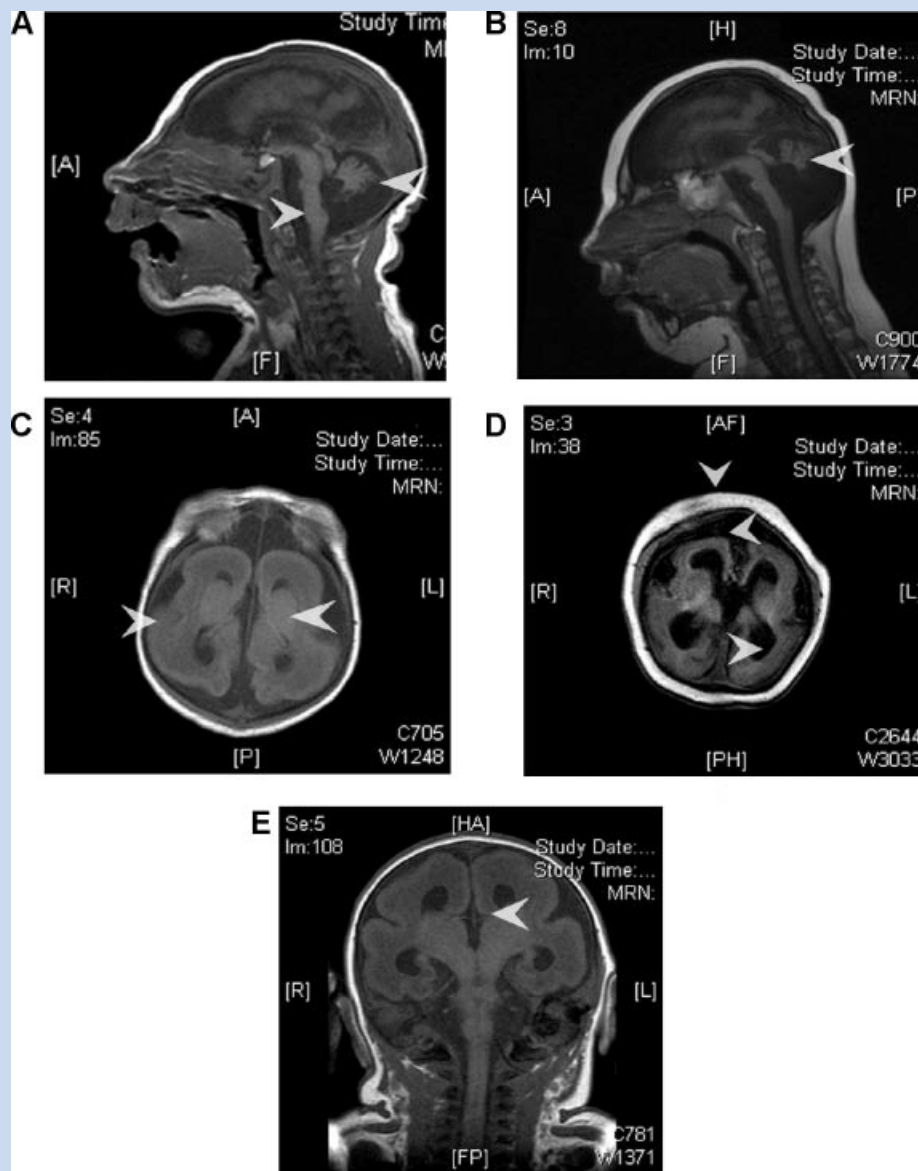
Selected MRI images from patient (after birth A,B,E) and during follow up (C,D). Sagittal T1 (A) weighted sequences show severe microcephaly (frontal sloping), cerebellar atrophy, and a Dandy–Walker cyst (<arrowhead), and abnormal brain stem morphology (arrowhead). Axial T1 (B) weighted sequences show the smooth pachygyric cortex (lissencephaly—>arrowhead) and poorly differentiated deep gray nuclei (<arrowhead). The coronal T1 weighted sequence (E) shows a thinned corpus callosum (arrowhead). Follow-up studies (C) show progression of cerebellar atrophy and posterior fossa abnormalities noted earlier (arrowhead). Axial T1 weighted sequences (D) show the thickening of the calvarium (arrowhead down), cerebral atrophy (<arrowhead), and ventriculomegaly (>arrowhead) indicating continued loss of gray-white matter thickness and ex vacuo ventricular enlargement.
